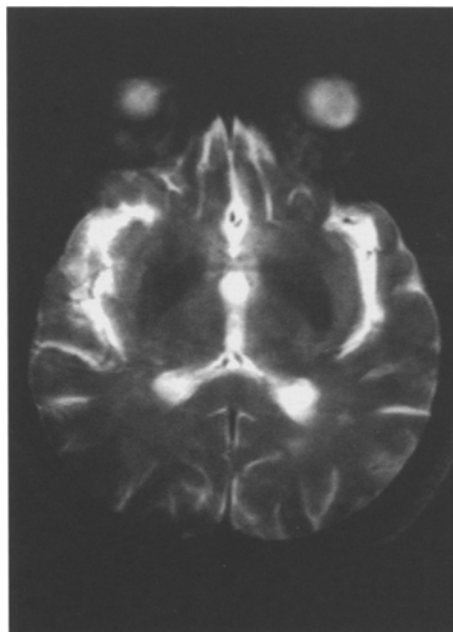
Follow-up MR examination. T2-weighted axial image at a level comparable with that of Figs. 1a and b. The area of right peritrigonal hyperintensity has almost completely disappeared (compare with Fig. 1b)
